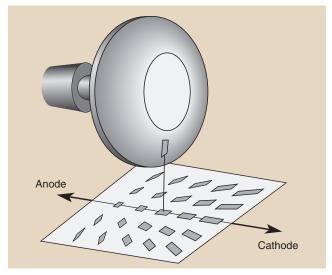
The effective focal spot changes size and shape across the projected x-ray field.
